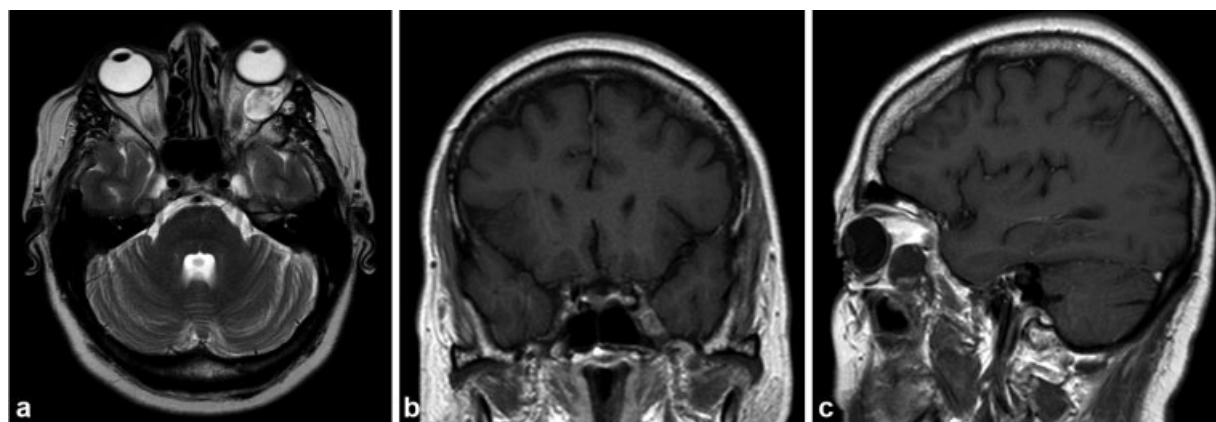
Postoperative images, after the first surgery. Magnetic resonance imaging still shows an orbital lesion. (a) Axial T2-weighted image, still showing the hyperintense lesion in the extraconal lateral region of the left orbit. (b) Coronal T1-weighted gadolinium-enhanced image, showing the resection performed in the first surgery. (c) Sagittal T1-weighted gadolinium-enhanced image from tumor, measuring 1.9 cm in its largest diameter, without impregnation by the gadolinium.
